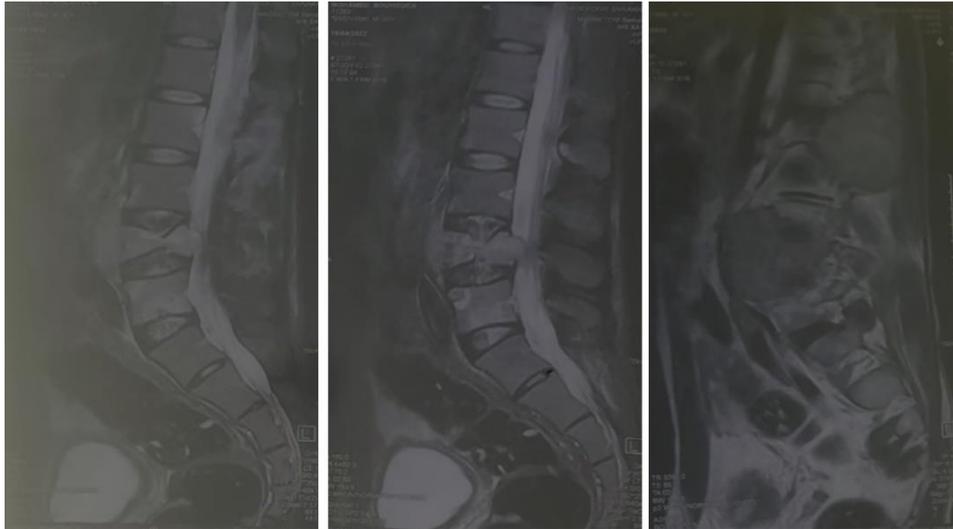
Sagittal lumbar MRI: Tumoral process of L4 vertebral body, the posterior arch of L2 and infiltrating the iliopsoas muscle
